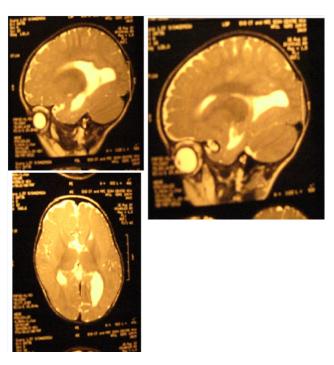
MRI brain (images of case no. 7) showing agenesis of the corpus callosum and colpocephaly
